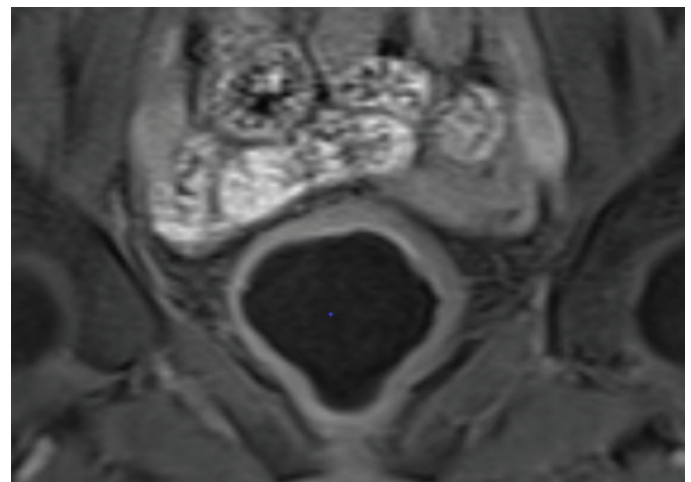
Magnetic resonance imaging of Case 1
